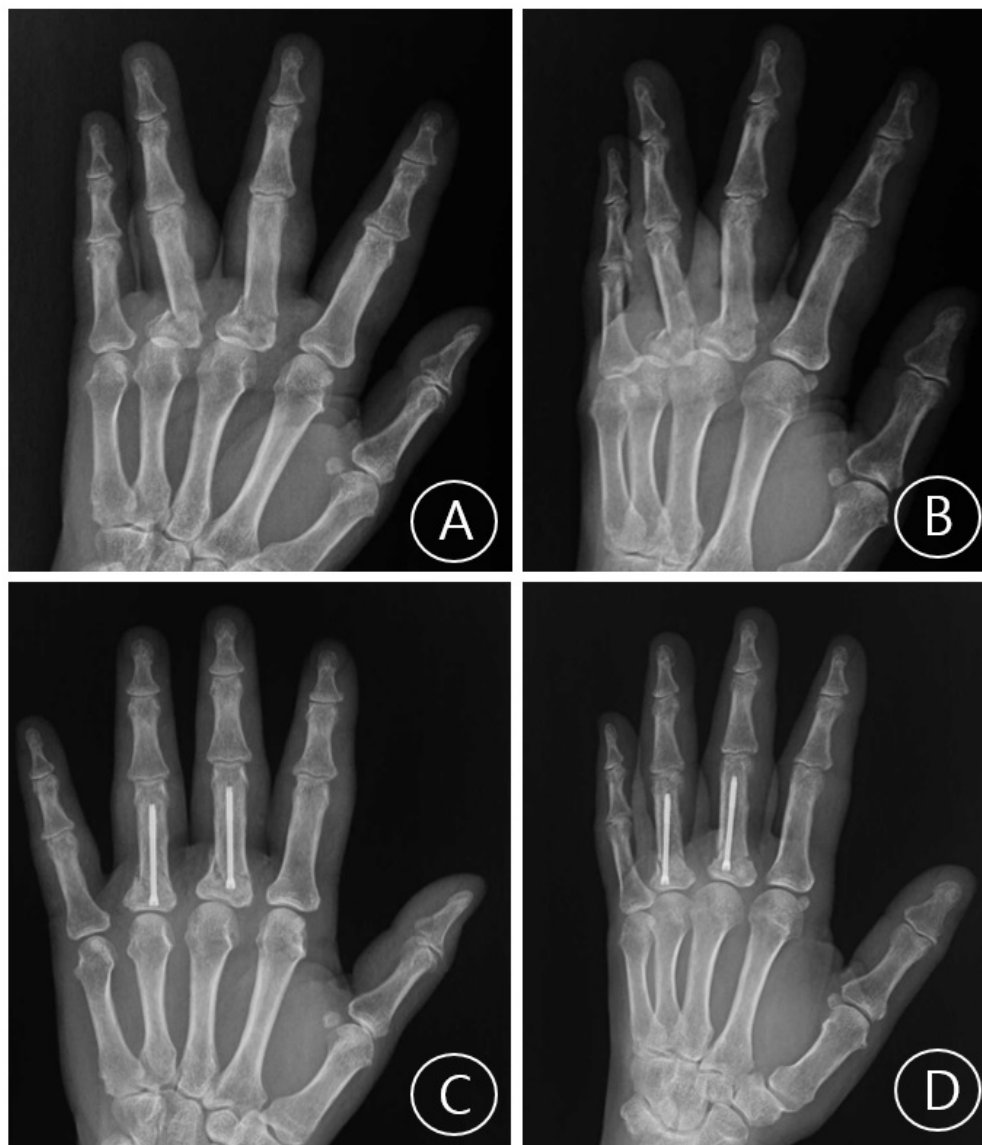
A case of a left third digit transverse proximal phalanx fracture. (a) Preoperative plain radiograph PA view; (b) Preoperative plain radiograph oblique view; (c) Postoperative plain radiograph PA view taken at last follow-up visit; (d) Postoperative plain radiograph oblique view taken at last follow-up visit.
